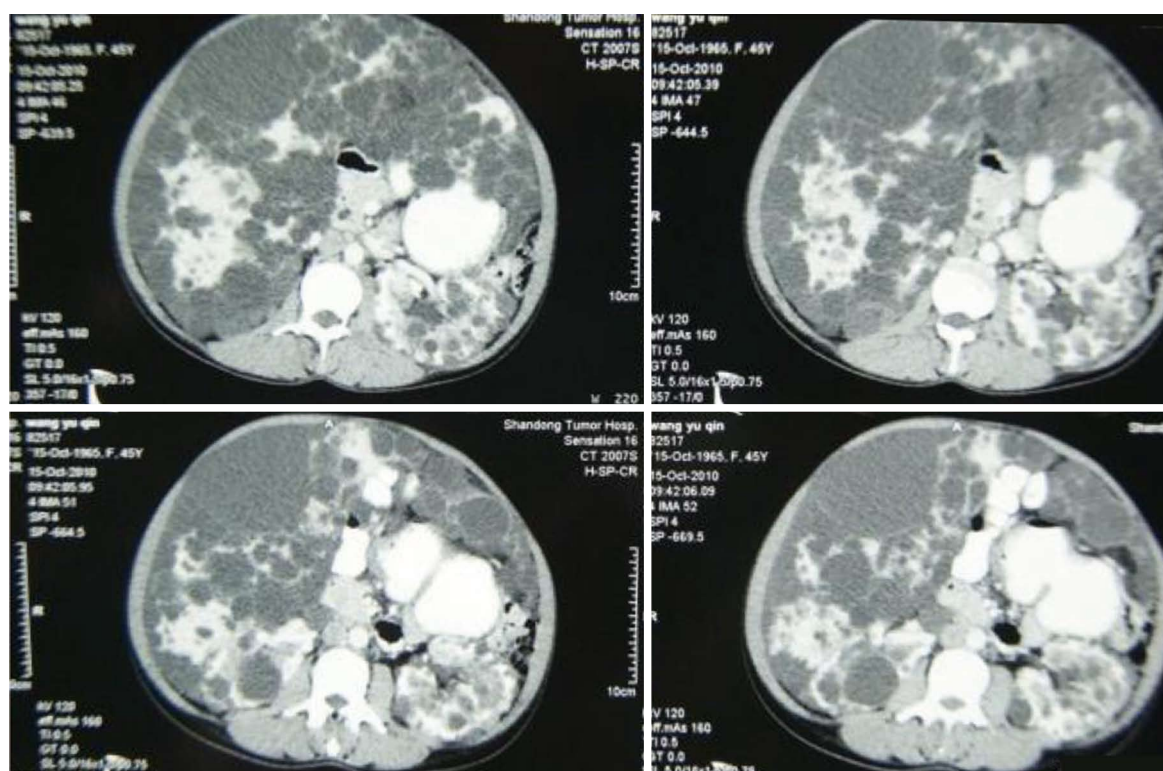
Computed tomography images.
